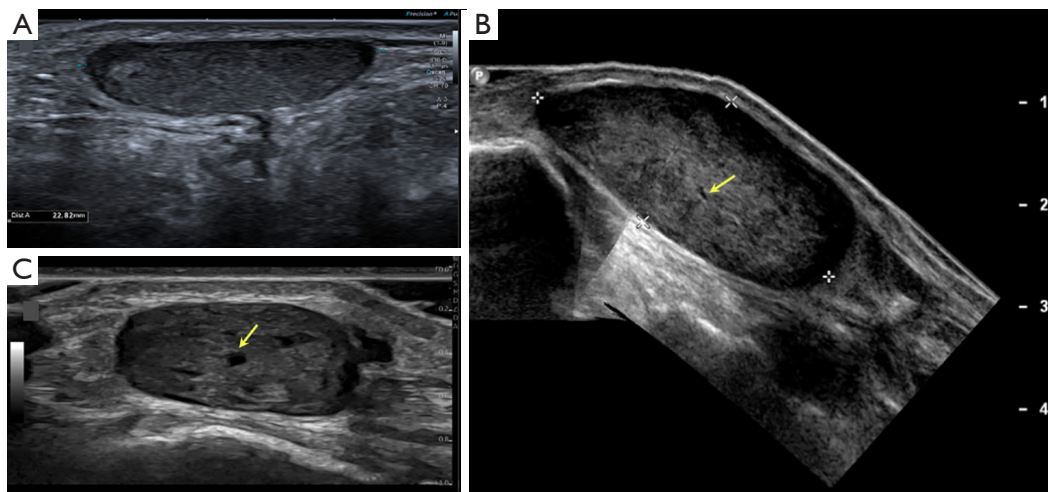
B mode US typical angioleiomyoma pattern in three different patients: (A) female, 30 years old, longitudinal image of the left ankle; (B) male, 42 years old, longitudinal image of the ankle; (C) female, 52 years old, angioleiomyoma of the hand. All of them are subcutaneous solid and oval tumors, with smooth or lobulated well defined margins and a homogeneous and hypoechoic background, showing small lineal anechoic images that correspond to small vessels (yellow arrows). US, ultrasonography.
